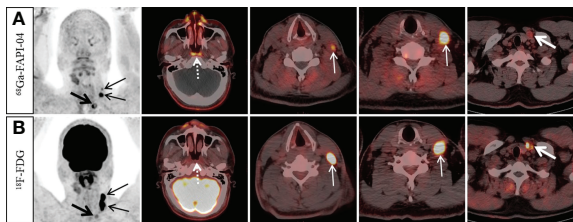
A 49-year-old man with nonkeratinizing differentiated carcinoma. <sup>68</sup>Ga-FAPI-04 PET/CT showed intensive <sup>68</sup>Ga-FAPI-04 uptake in the posterior nasopharyngeal wall (A, dotted arrow, SUVmax 3.8), <sup>18</sup>F-FDG PET/CT showed no abnormal <sup>18</sup>F-FDG uptake in the primary tumor (B, dotted arrow). Moreover, <sup>68</sup>Ga-FAPI-04 PET/CT reveals higher tracer uptake than <sup>18</sup>F-FDG PET/CT in the left supraclavicular lymph node (A, thick arrow, SUVmax 9.4 vs. B, thick arrow, SUVmax 3.8), but the tracer uptake of left cervical (level III) lymph nodes was lower than that of <sup>18</sup>F-FDG PET/CT (A, thin arrow, SUVmax, 4.5–11.0 vs. B, thin arrow, SUVmax, 17.7–19.4).
